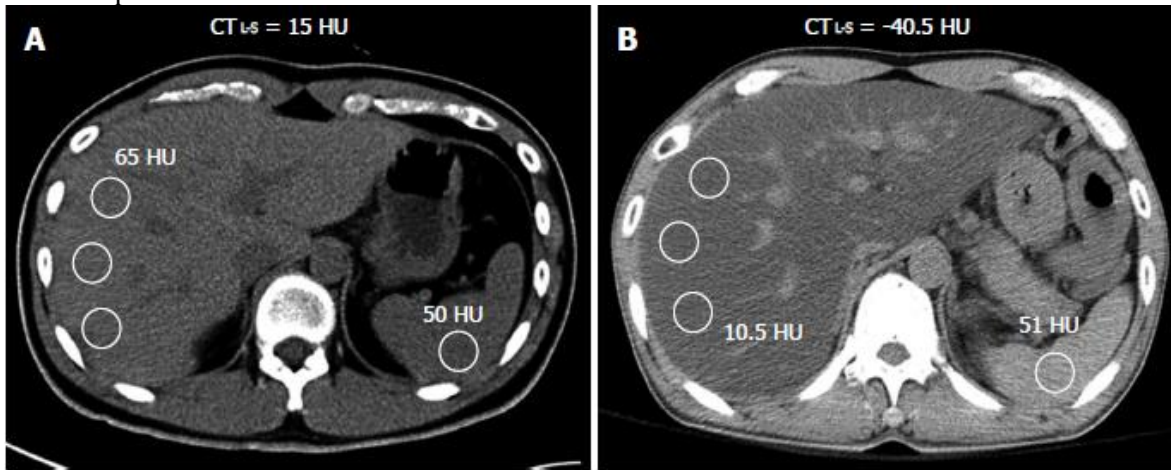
Computed tomography evaluation of hepatic steatosis using computed tomographyL-S index.
